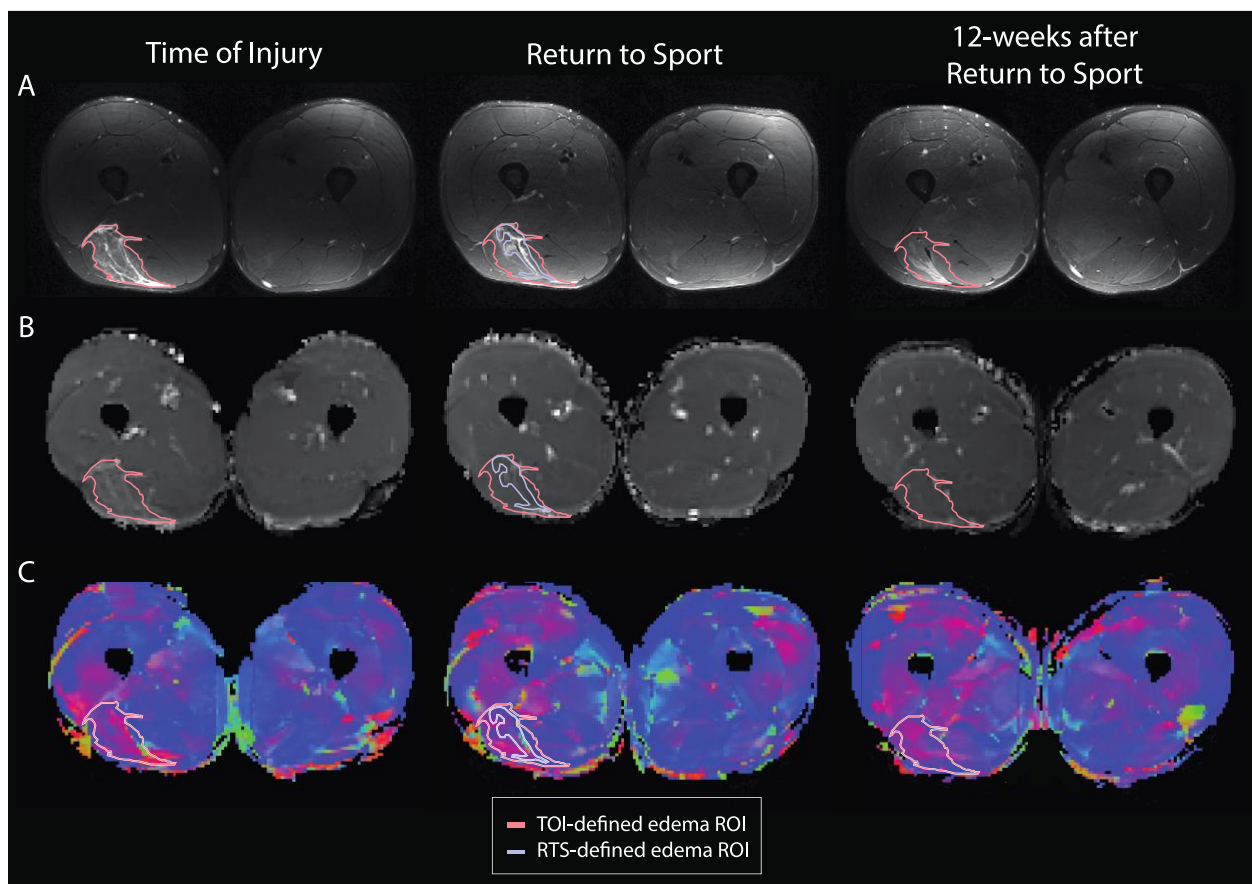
Representative imaging data from one participant at time of injury (TOI), return to sport (RTS), and 12 weeks after RTS; A.) T2-weighted, B.) mean diffusivity, and C.) primary eigenvalue maps along principal direction. Manually defined edema mask at TOI (peach) was registered to follow up scans to ensure a consistent region was compared across timepoints. Manually identified edema ROI mask at RTS (blue) used in Supplemental Material B.
